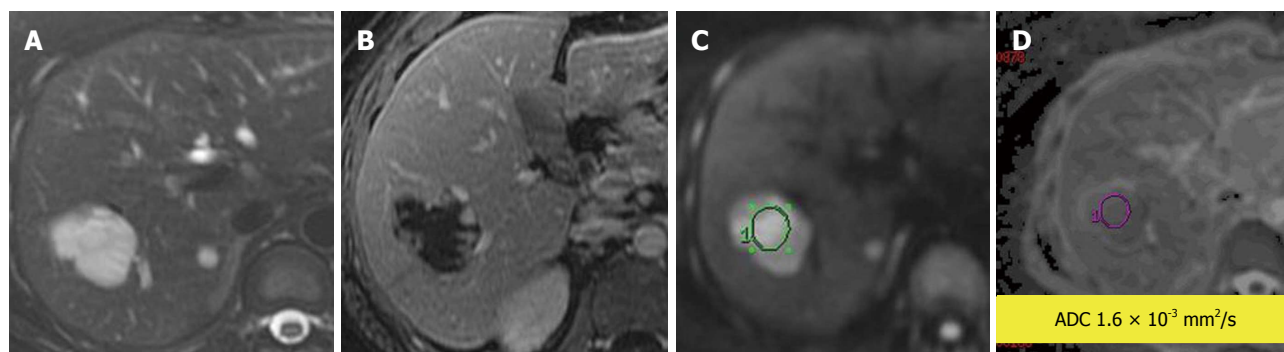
Cavernous hemangioma in the liver. A: Fat-suppressed T2-weighted (T2W) Fast Spin-Echo; B: Enhanced (arterial phase) T1-weighted gradient recalled-echo; C: Diffusion-weighted image; D: Apparent diffusion coefficient map (ADC) map. A cavernous hemangioma with a typical T2W hyperintense signal and enhancement (peripheral discontinuous on arterial post contrast phase) characteristics and $ADC = 1.6 \times 10^{-3} \text{ mm}^2/\text{s}$.
